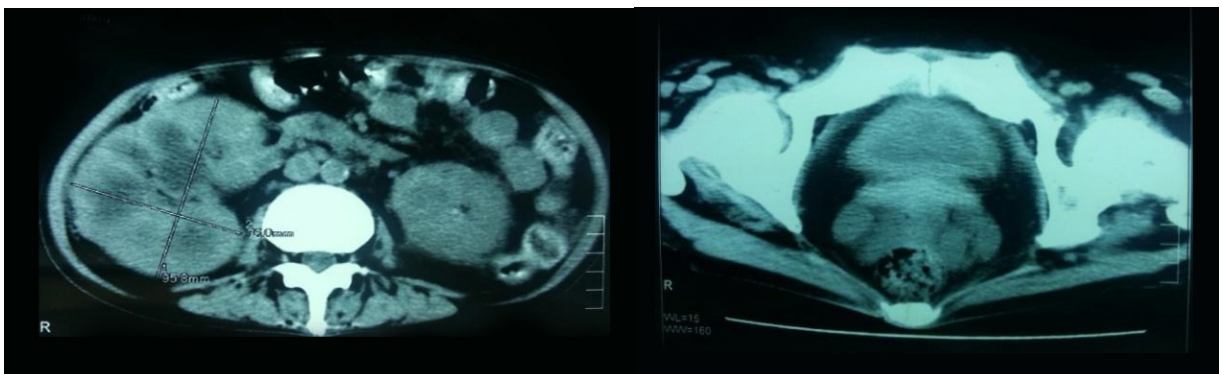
Abdominal CT scan with contrast: enlarging right kidney, with widening renal pelvicalyceal system, a small stone is visible in low pole (A) ; and thickening of bladder wall (B)
